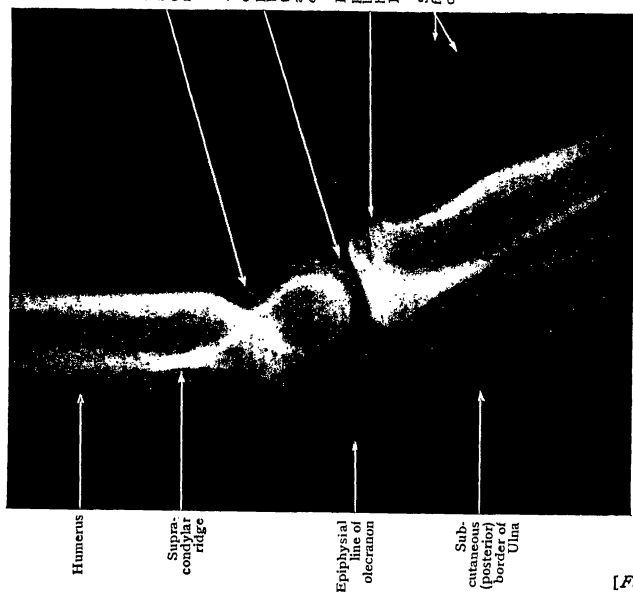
Lateral Radiograph of slightly flexed Elbow of girl aged 12. Note the uniting epiphyses of head of Radius and olecranon of Ulna.
